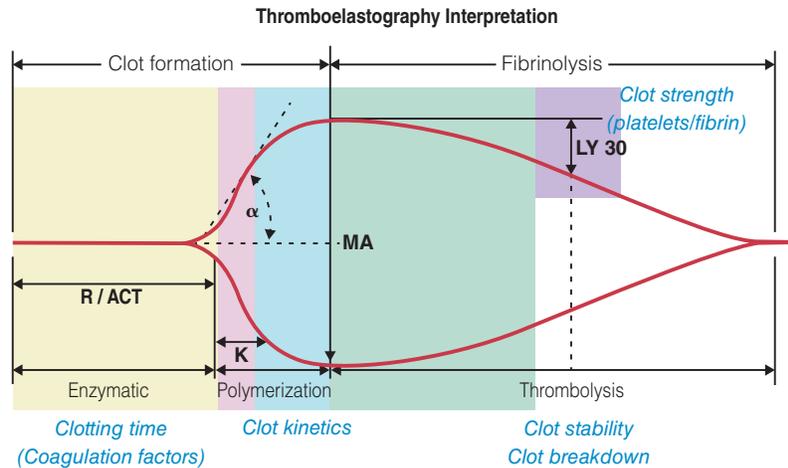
depicts a TEG waveform and its interpretation. The data obtained from TEG and ROTEM are similar, but not interchangeable, because of differences in the methods and nomenclature. The time it takes to start forming a clot (reaction [R] time in TEG, clotting time [CT] in ROTEM) is the time from sample placement until the tracing amplitude reaches 2 mm. The kinetic time (K-time) in TEG, or clot formation time (CFT) in ROTEM, represent the time it takes for the clot to reach a fixed strength. Graphically, this is the time elapsed between the R-time and the point where the tracing amplitude reaches 20 mm. The angle is the speed of fibrin accumulation and is created from the developing curve from the point of clot initiation. Maximal amplitude (MA) in TEG or maximal clot firmness (MCF) in ROTEM is a function of the fibrin and platelet bonding. This represents the strongest point in the clot formation and correlates with platelet function. Lastly, clot dissolution is measured to evaluate for fibrinolysis. In TEG, lysis is measured at 30 and 60 minutes after the MA is recorded. In ROTEM, the lysis index 30 represents the percent reduction from MCF 30 minutes after CT.³⁹
